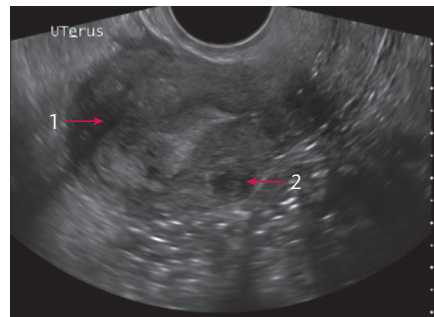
Transvaginal ultrasound picture demonstrating uterus in sagittal section:
